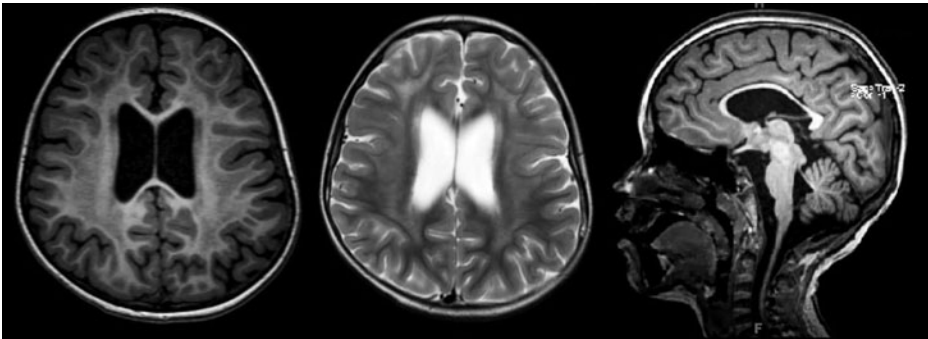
A 6 year-old girl with infantile Alexander disease. Axial T1-MPR (left) and T2 (center) images from a brain MRI show white matter changes with increased T2 and decreased T1 signal intensity, most prominent anteriorly and largely sparing the subcortical and periventricular white matter. There is a periventricular rim with high signal on T1-weighted images and low signal on T2-weighted images. Sagittal T1-MPR images (right) show corpus callosum, frontal and parietal cortical, cerebellar and pontine atrophy. Also noted is thickening of the inferior aspect of the tectum that may represent an incidental glioma.
